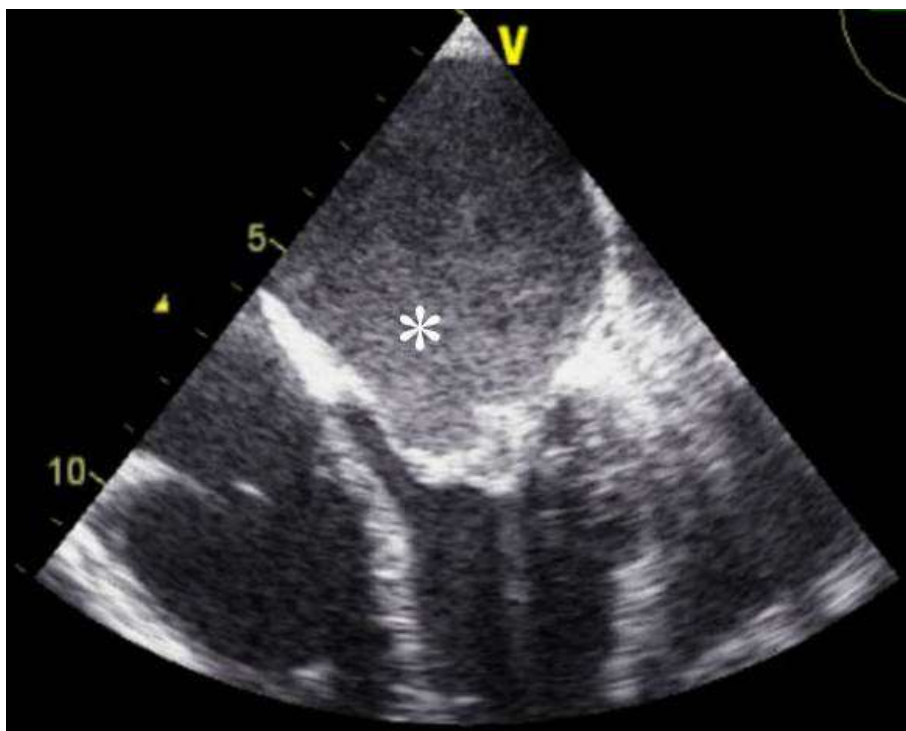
Left atrial spontaneous echocontrast finding (*) in transesophageal echocardiography (courtesy of Rui Martins, MD, Cardiology Department).
